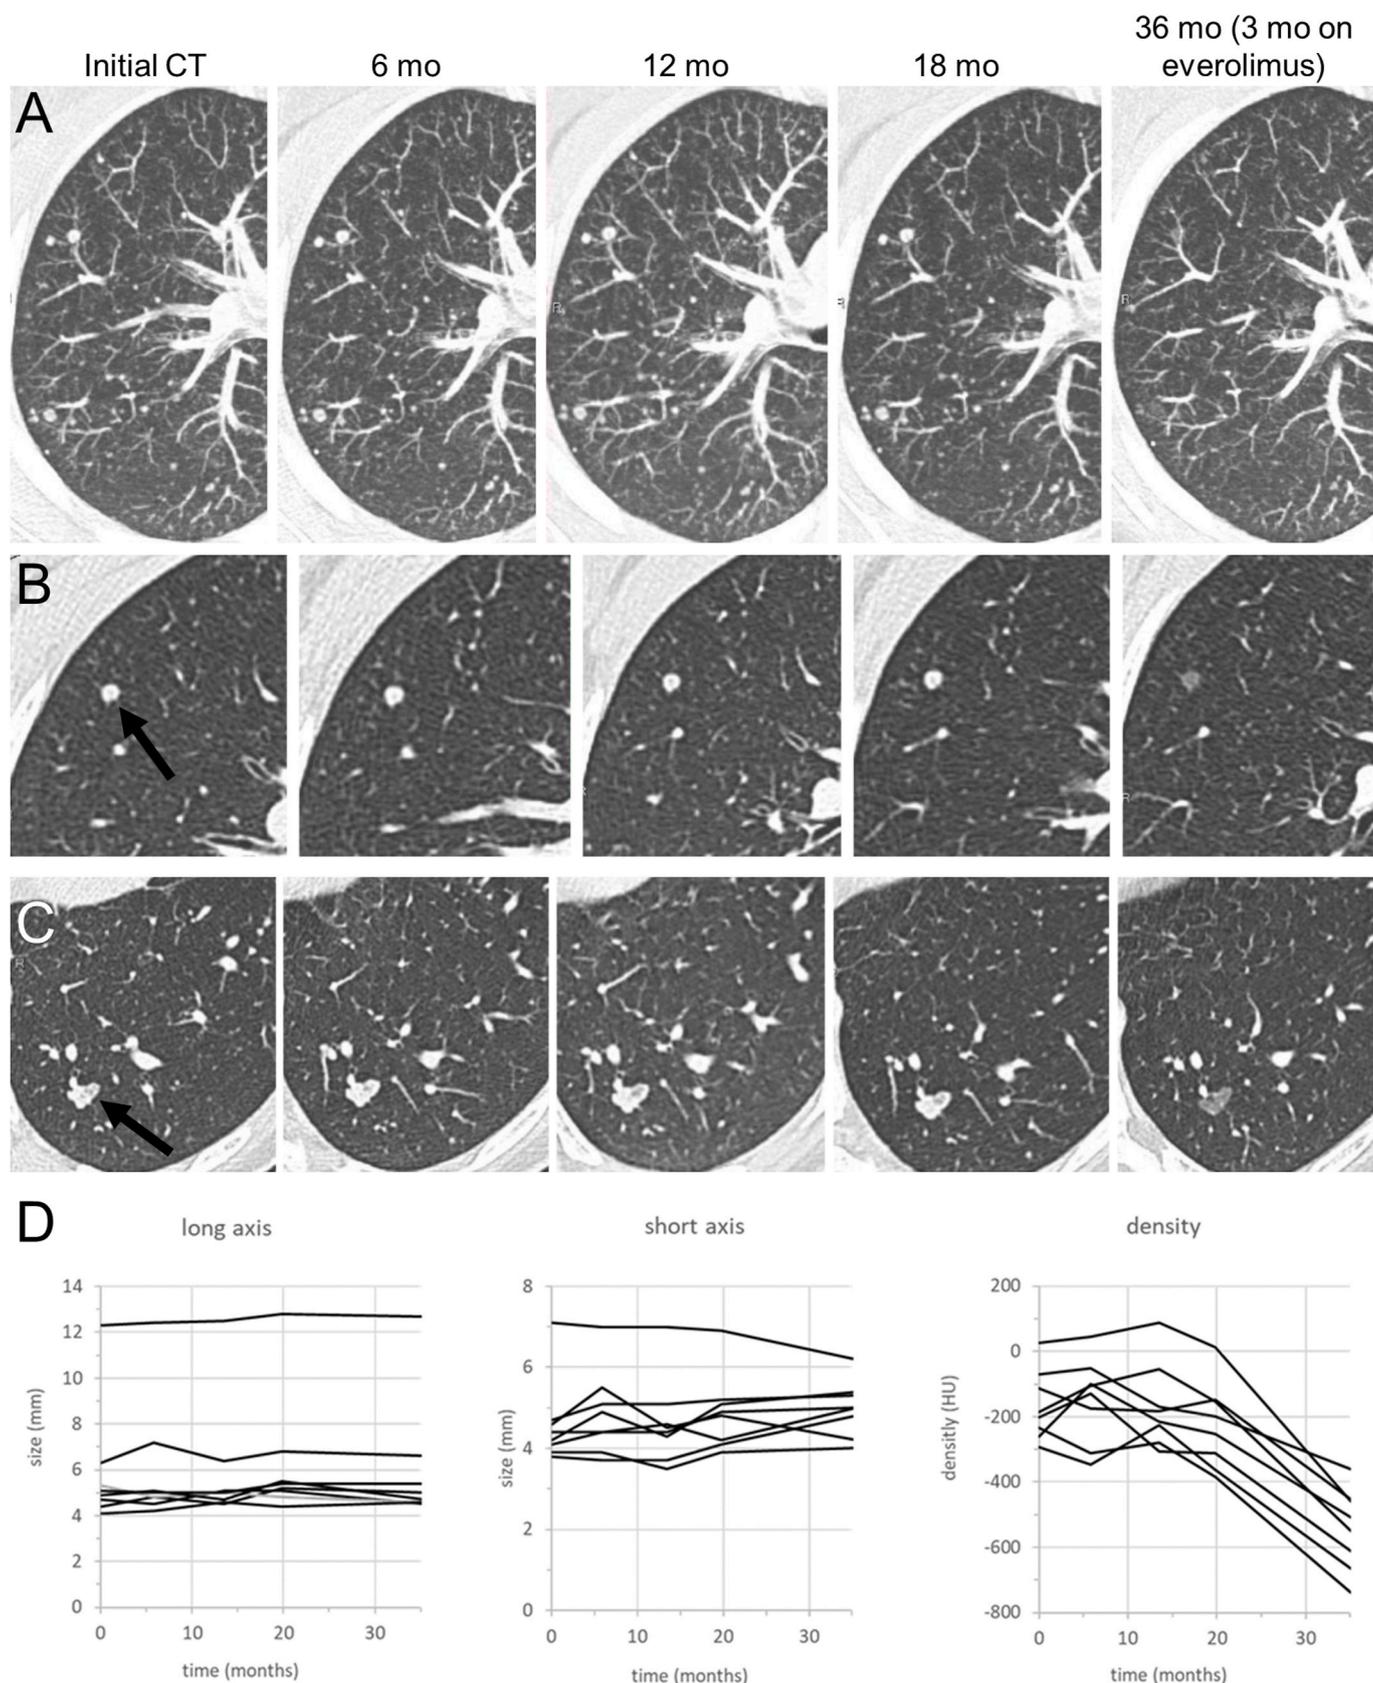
Chest HRCT at 0, 6, 12, 18 and 36 months (mo): stability in size, shape and density of numerous small pulmonary nodules with a random distribution on the 4 first HRCTs, followed by a significant decrease in density of all pulmonary nodules at 36 months, i.e. 3 months after everolimus initiation (A). Similar observation focused on selected nodules in the right upper lobe (B) and left lower lobe (C). Follow-up of dimensions (long and short axis) in millimeters (mm) and density using Hounsfield Unit (HU) values of the 8 most easily perceptible solid nodules, showing no change in size over time before (first 4 HRCTs) and after (last HRCT) everolimus initiation, but a decrease in density on the last HRCT performed 3 months after treatment onset (D).
